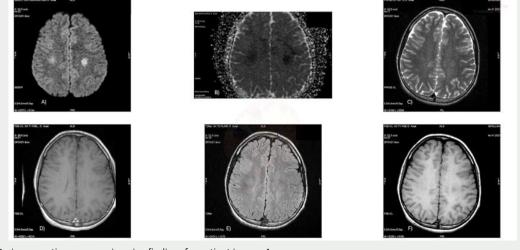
Brain magnetic resonance imaging findings for patient in case 4
